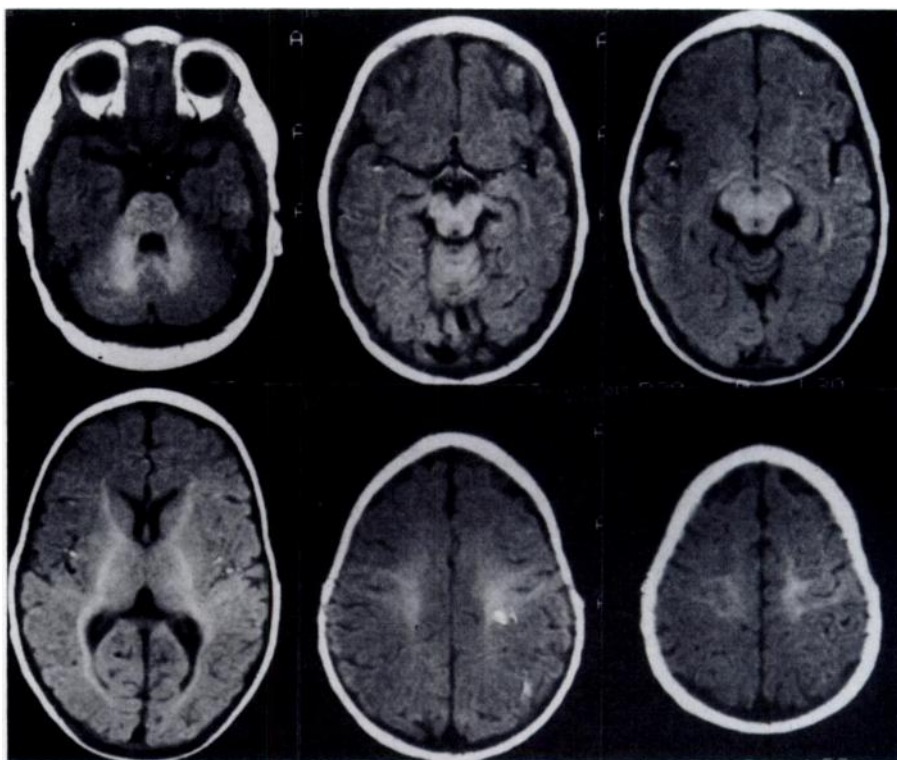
MR images in the brain of a healthy 3-month-old infant.  $T_1$ -weighted images show high signal intensity, indicating maturation of the middle cerebellar peduncles and the ventral aspect of the brain stem. Moreover, white-matter maturation is now seen in the anterior limbs of the internal capsule, and there is more extensive maturation of the optic radiations. In the centrum semiovale there is crude arborization of the high signal intensity into the subcortical white matter of the paracentral gyri. The relative high signal intensity of the paracentral gyri themselves has receded by this age.
